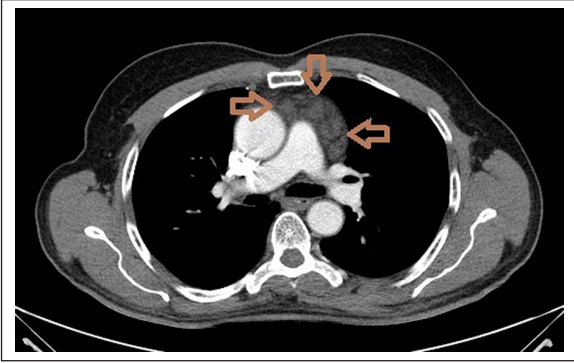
Computed tomography scan showing a hypodense tumor (arrow) in the anterior mediastinum.
